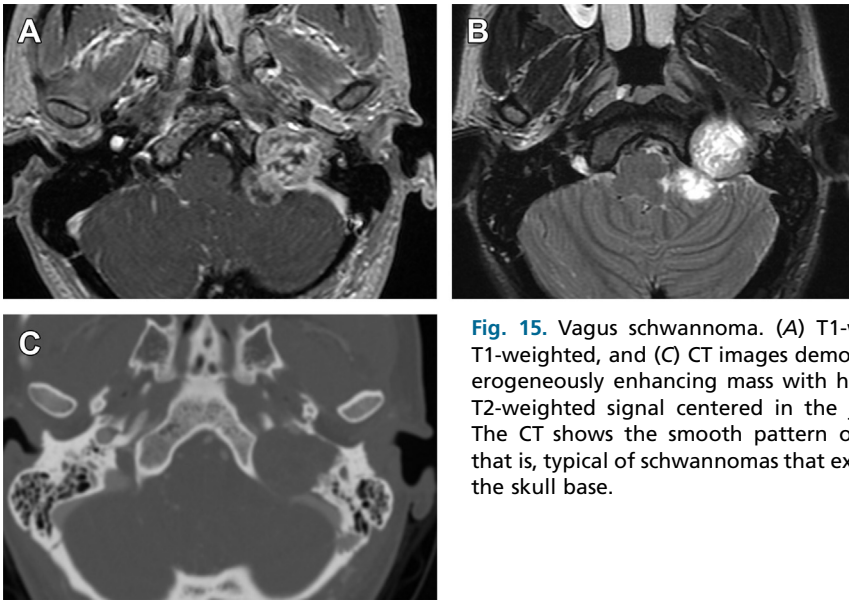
Vagus schwannoma. (A) T1-weighted, (B) T2-weighted, and (C) CT images demonstrate a heterogeneously enhancing mass with heterogeneous T2-weighted signal centered in the jugular fossa. The CT shows the smooth pattern of remodeling that is, typical of schwannomas that extend through the skull base.
